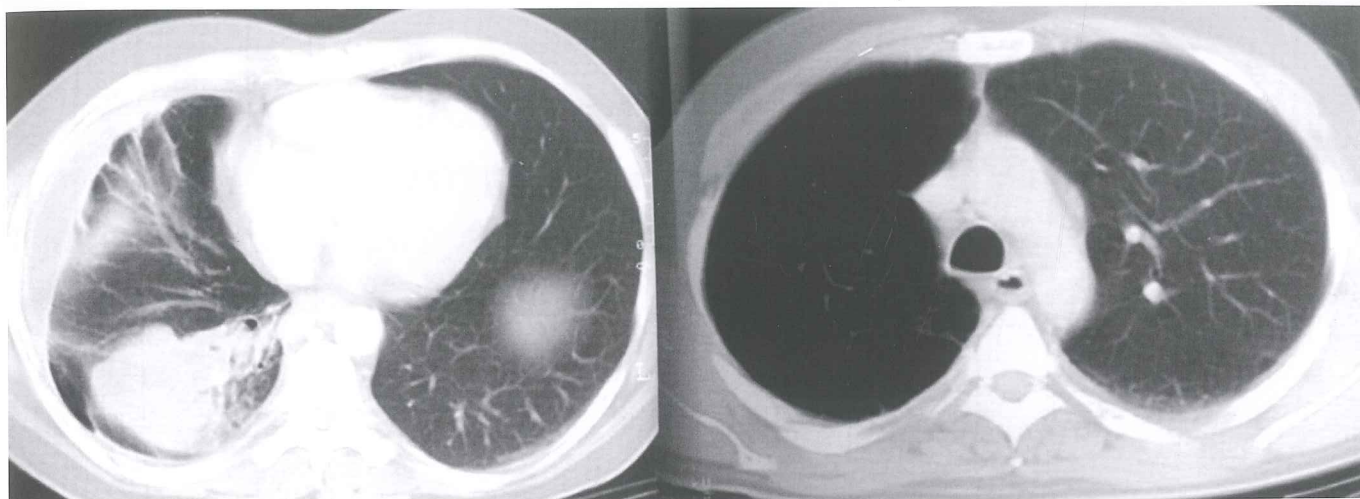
Computed tomography shows right lower lobe tumor with right upper lobe emphysematous changes. On the same image, a bulla can be seen on the posterior segment of the left upper lobe.
